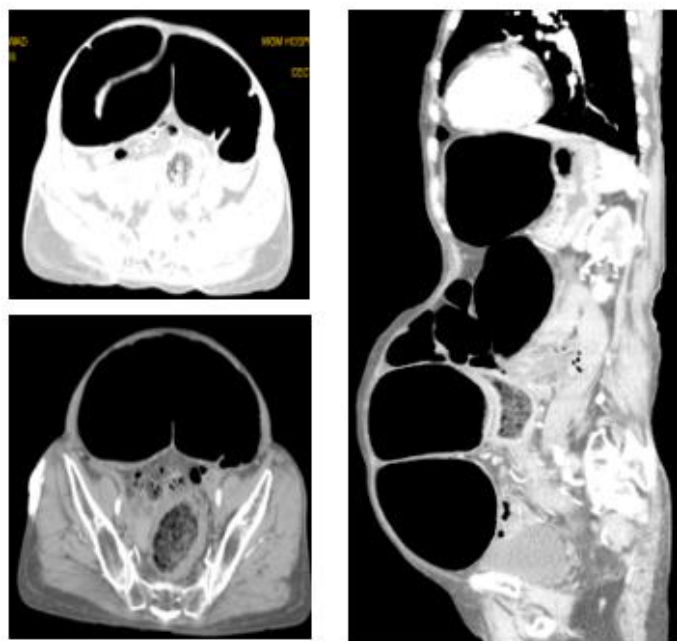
CT abdomen showing sigmoid volvulus with severely dilated large bowel loops impending rupture and stercoral colitis with fecal impaction of rectum
